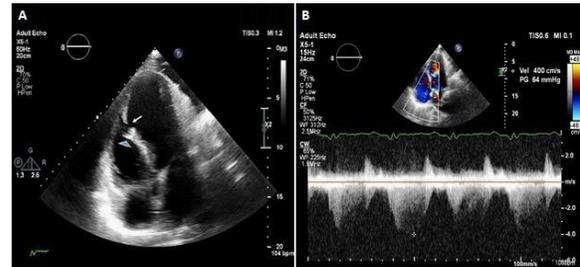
Echocardiographic study showing: A- septal rupture (arrow), located at 14mm from the apex, and 9mm from the moderator band (arrow head). B- Tricuspid regurgitation Doppler study, with TRG: 64mmHg. C- Color Doppler study showed significant shunt from LV to RV. D- Trans-gastric view in TEE, showing multiple defects in the septum: two larger and two small and flame-like color signals
